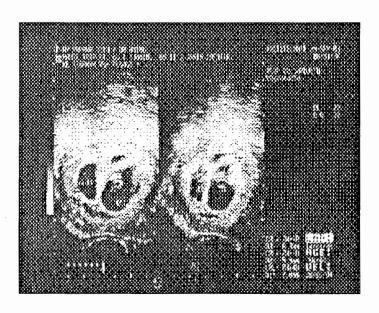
Ultrasound investigation image of 7 weeks gestation.Note, 2 gestational sacs, 3 fetuses.
